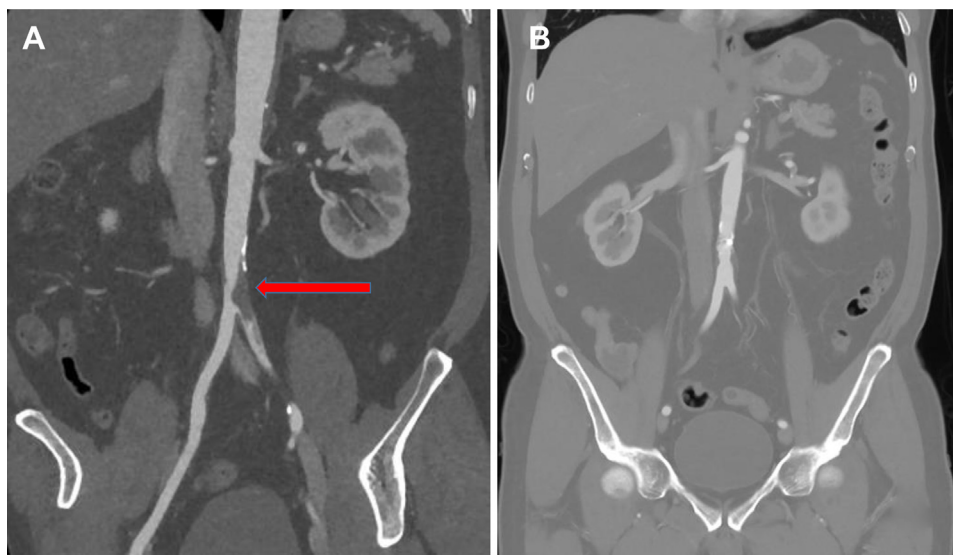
A, Preoperative computed tomography scan demonstrating the presence of aortic thrombus (*red arrow*). B, Postoperative computed tomography angiogram demonstrating no residual thrombus.
